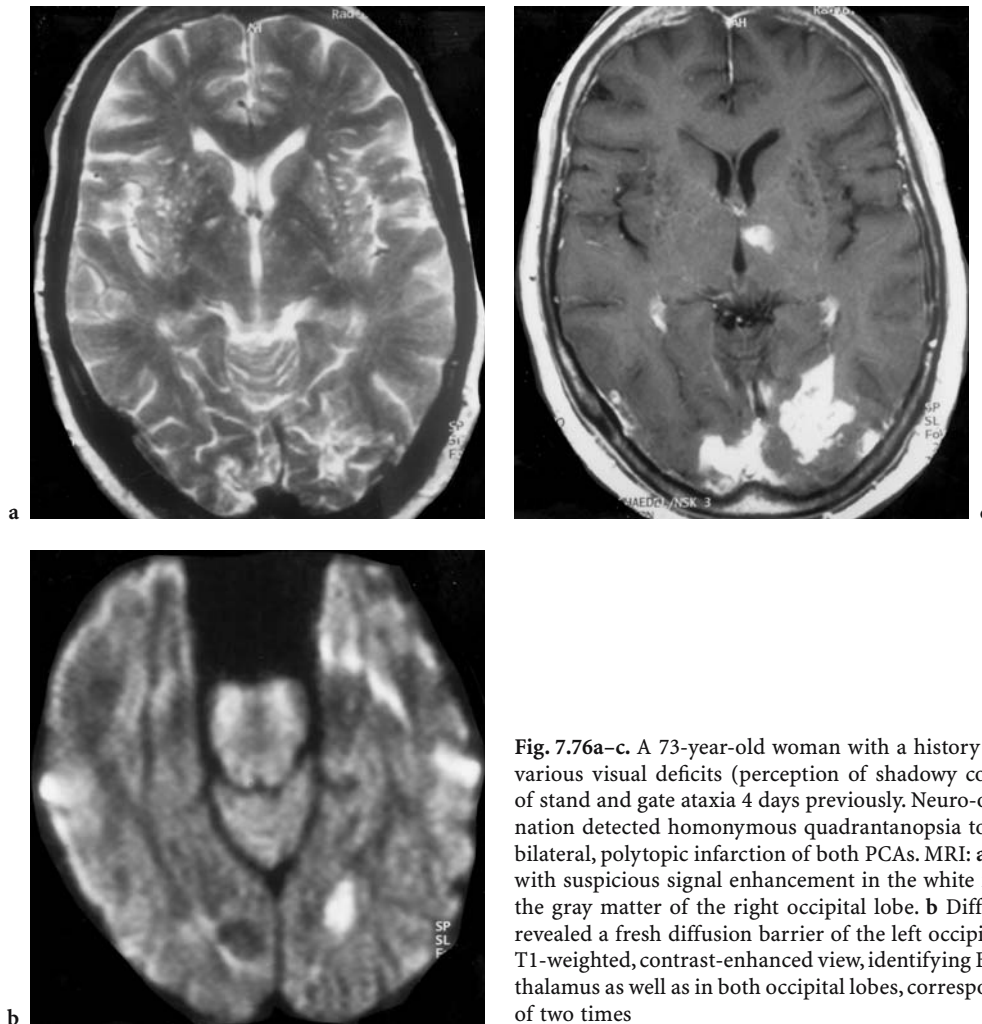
A 73-year-old woman with a history of rheumatoid arthritis, various visual deficits (perception of shadowy contours only), and onset of stand and gate ataxia 4 days previously. Neuro-ophthalmological examination detected homonymous quadrantanopsia to left inferior. Diagnosis: bilateral, polytopic infarction of both PCAs. MRI: a Axial T2-weighted view with suspicious signal enhancement in the white matter of the left and in the gray matter of the right occipital lobe. b Diffusion-weighted imaging revealed a fresh diffusion barrier of the left occipital white matter. c Axial, T1-weighted, contrast-enhanced view, identifying BBB disruption in the left thalamus as well as in both occipital lobes, corresponding to two infarctions of two times
